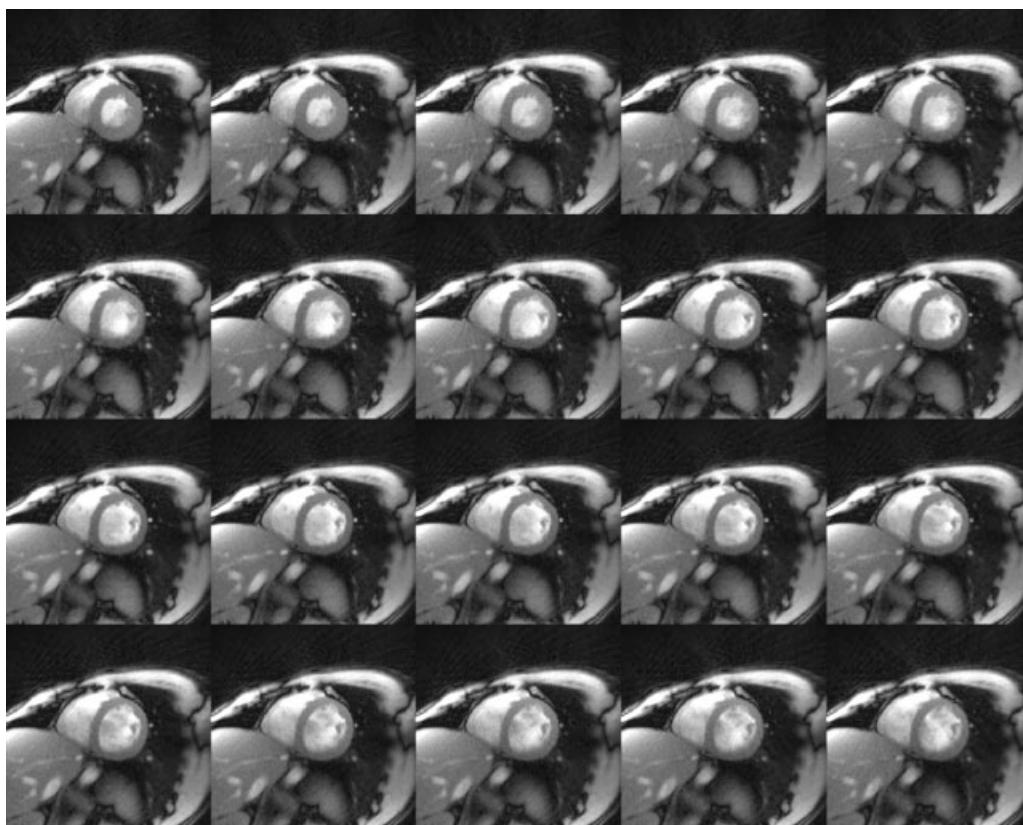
Twenty consecutive frames from a real-time MRI data set of the human heart, acquired with 85 spokes per frame and reconstructed with nonlinear inversion using eight Newton steps. For other parameters, see Fig. 2.
